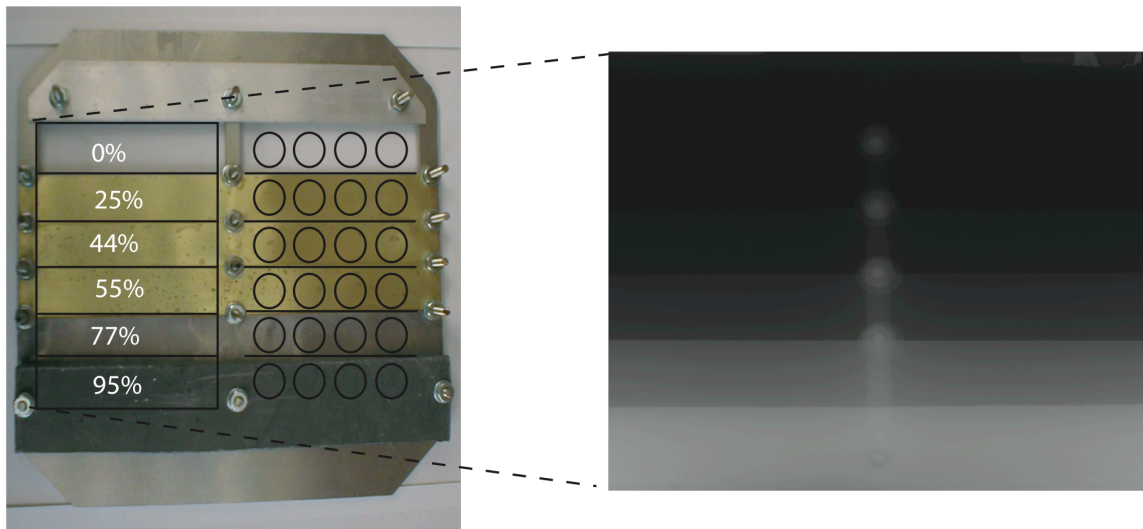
Photograph and X-ray film of the multi-attenuator insert.
